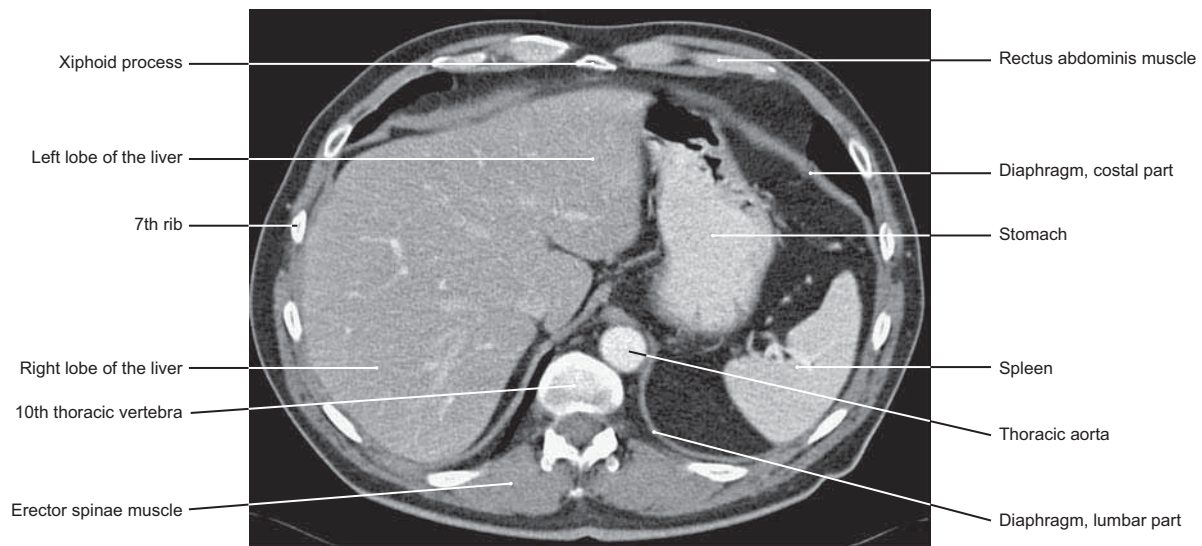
CT Transverse Section of the Abdomen at the Level of T10
